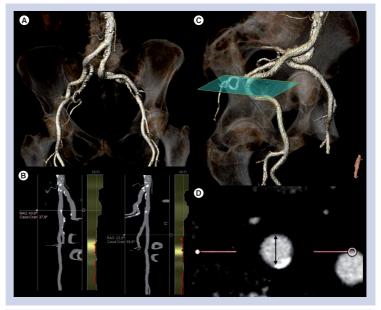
Evaluation of peripheral arteries with multidetector computed tomography. (A) Shows an example in volume-rendered image, highlighting the tortuous course of the vessel. Using the center-line approach, the distribution of calcification along the vessel (stretched view in (B)) and the internal luminal diameter of the vessel (double oblique transverse view in (D)) can be accurately assessed. In addition, the exact angulation within the artery can be measured on the volume-rendered image with multidetector computed tomography (C). Post-processing imaging software: 3mensio ValvesTM, version 4.2., 3mensio Medical Imaging BV, Bithoven, The Netherlands.
